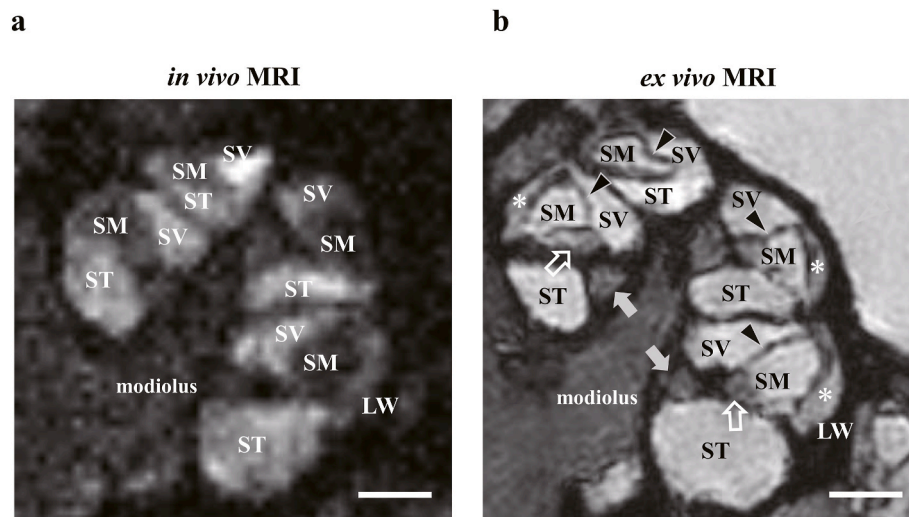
Representative normal right cochlea images of *in vivo* and *ex vivo* MRI (a) *in vivo* MRI image. The boundary between the endolymph space and perilymph space was clear and distinguishable. However, the boundaries of other structures were unclear. (b) *Ex vivo* MRI image. The boundary between the scala vestibuli and scala media was clearly seen by Reissner's membrane. The structures of the organ of Corti and stria vascularis can now be seen more clearly. SV: scala vestibuli, ST: scala tympani, SM: scala media, and LW: lateral wall. Black arrowheads: Reissner's membrane, white arrows: the organ of Corti, asterisks: stria vascularis and grey arrows: osseous spiral lamina, modiolus. Scale bar: 500 μ m.
